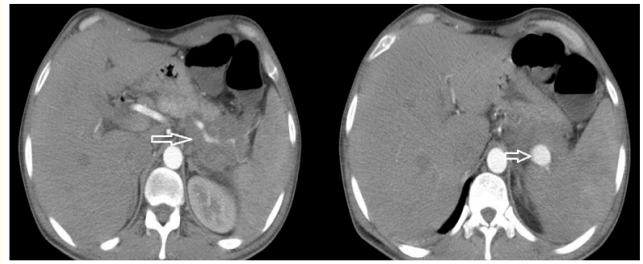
Abdominal CT showing: the white arrow in the left the body and tail massforming lesion, and the white arrow in the right de splenic artery pseudoaneurysm.
